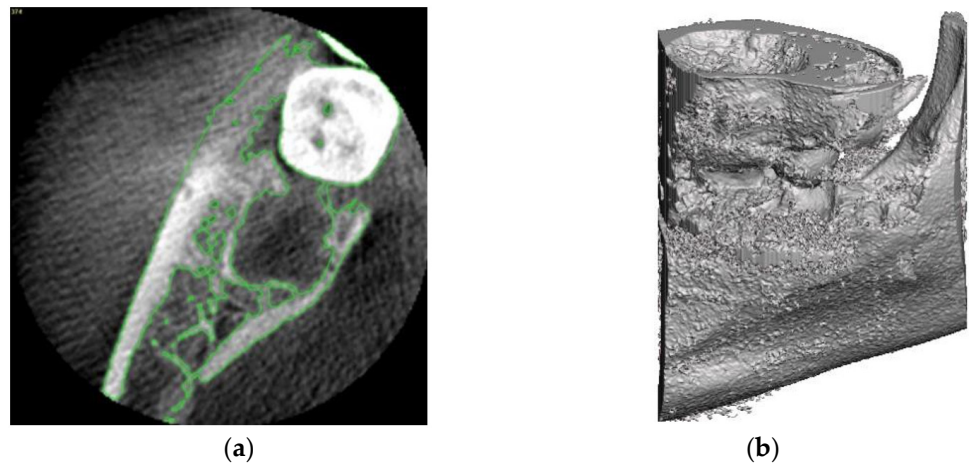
(a) Segmentation on the CBCT image and (b) reconstructed surface 3D model of the jaw.
